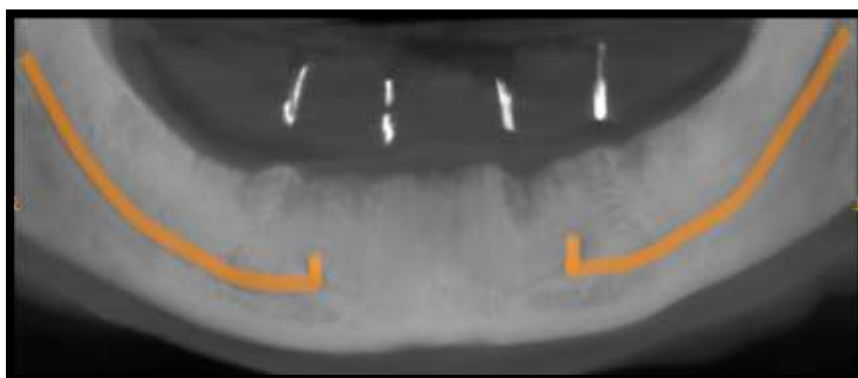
Preoperative CBCT image
